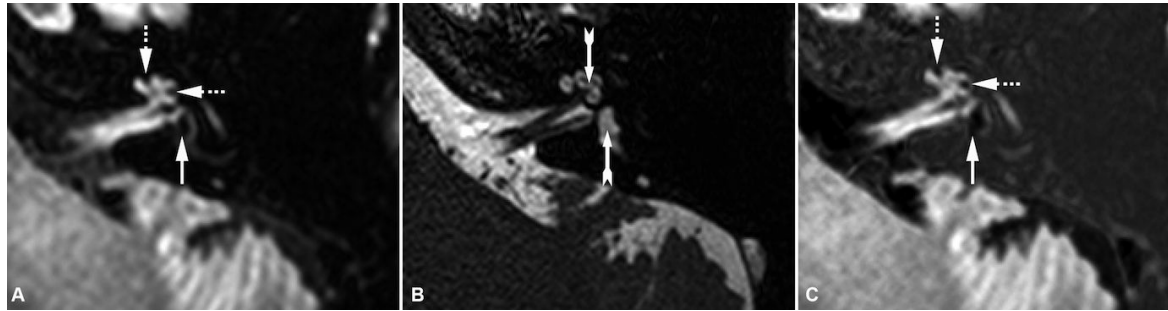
Example of the postprocessing method with fusion of the two MRI sequences. Heavily-Weighted T2 sequence (B) was subtracted from 3D-FLAIR sequence (A) to achieve the sequence used to highlight endolymphatic hydrops (C) leading to a decrease in the temporal bone signal around the inner ear structures. As described in the text, CH (dotted arrows) was more easily separated from adjacent bone on the C image and appeared as a nodular dilatation of the endolymphatic canal. T2 sequence (B) didn't allow the distinction between perilymph and endolymph fluids (arrows).
